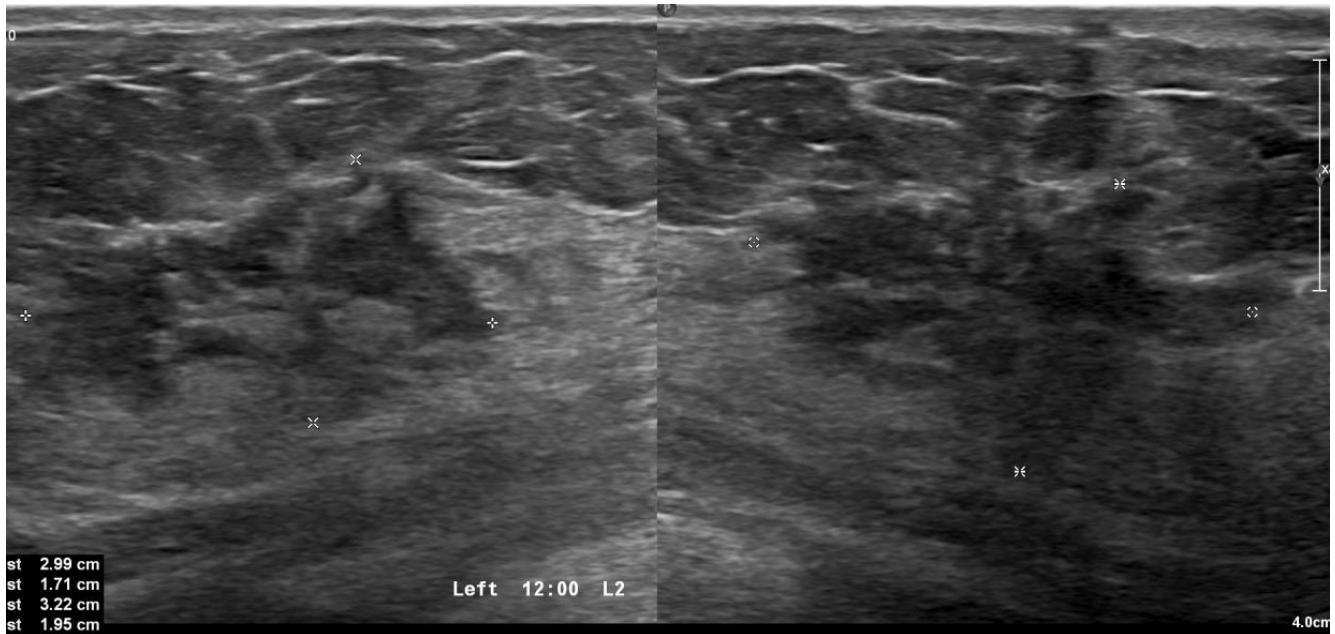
Ultrasound breast showing an irregular heterogeneous mass with indistinct and angulated margins.
